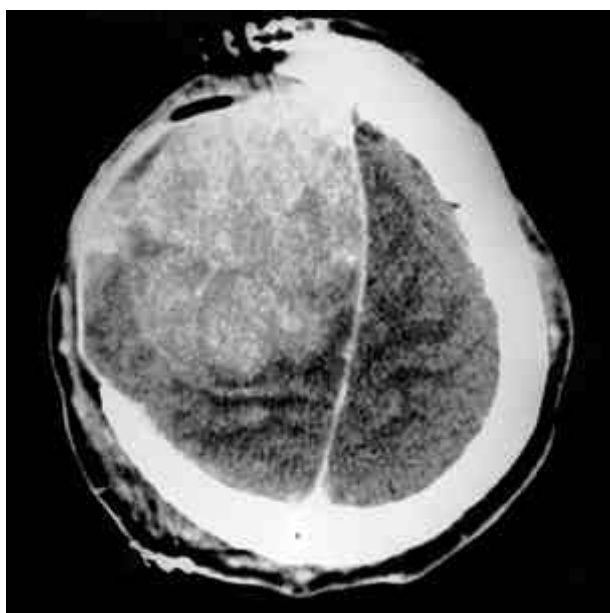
Enhanced axial CT, taken after first surgery before IORT, showed homogeneously enhancing residual tumor.
